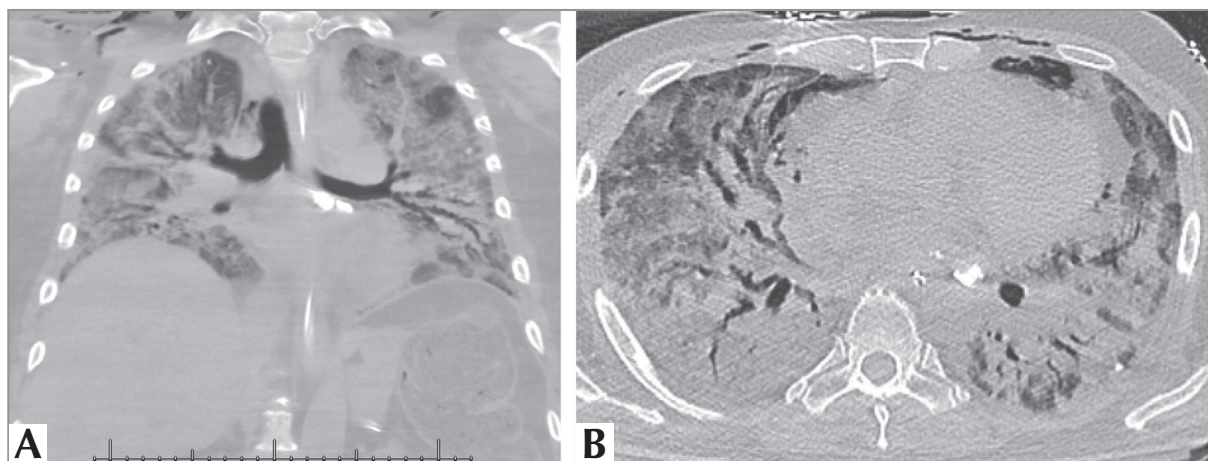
A. High-resolution CT (HRCT) images in coronal and B. Axial planes showing bilateral ground glass opacities with traction bronchiectasis.
